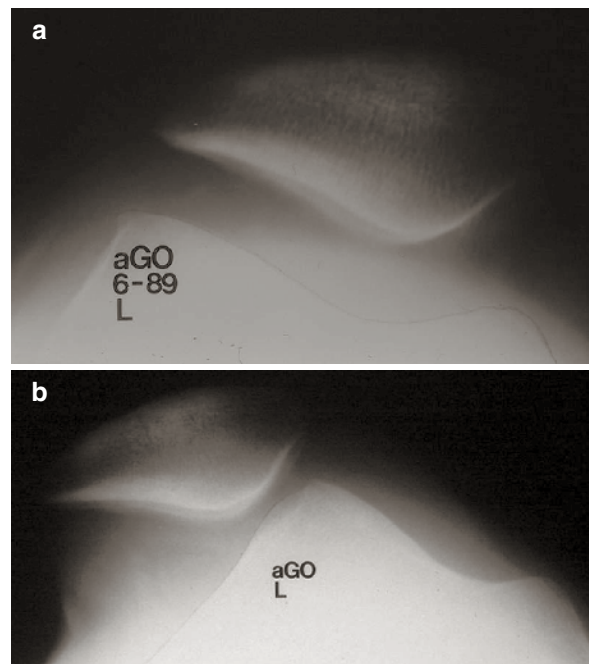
(a) Axial view of patient with anterior knee pain and apprehension and increased lateral excursion with lateral patellar stress. (b) Lateral stress radiograph of the patient with anterior knee pain, apprehension and increased lateral patellar excursion on stress examination. The radiograph clearly demonstrates complete lateral dislocation not recognized in (a)
